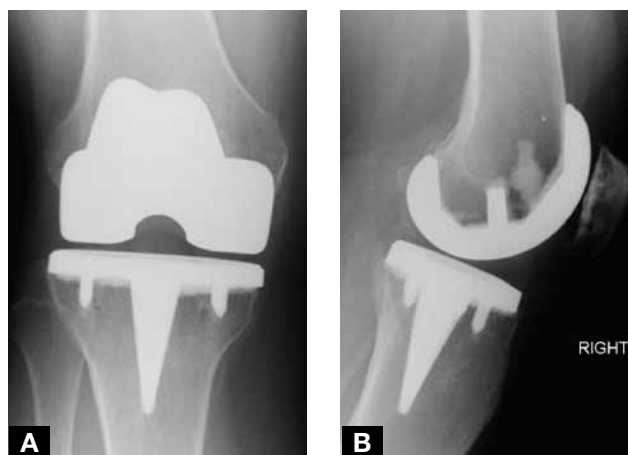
(A, B) At 14 years, radiographs of NK-II system with cemented fixation of femoral component and tibial baseplate with peripheral pegs.
